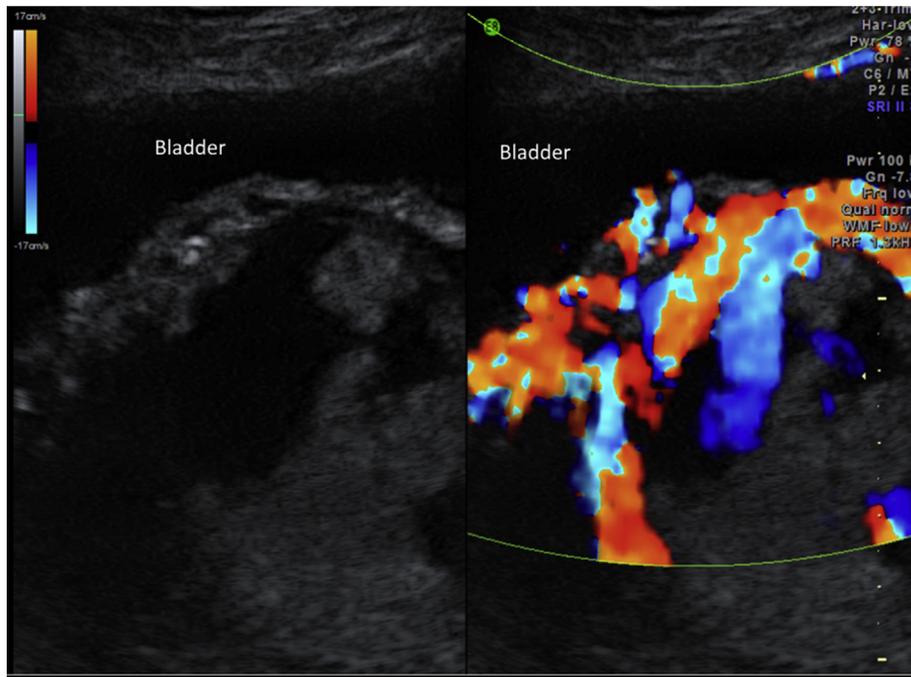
Large vascular lacunae on grey-scale ultrasound with increased vascularity on Colour Doppler mapping.
